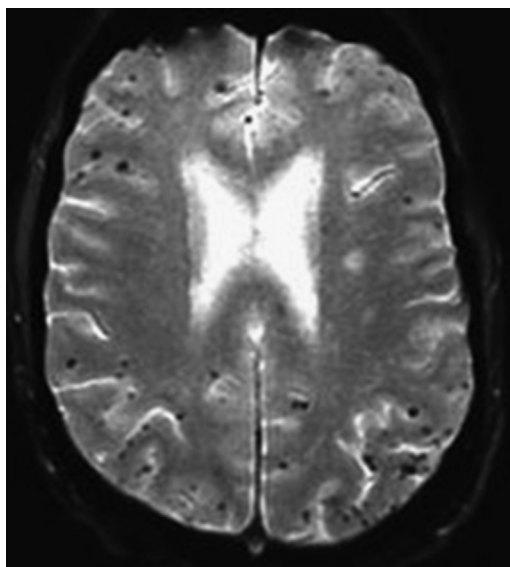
Magnetic resonance imaging of multiple cerebral microbleeds detected on spin echo gradient imaging. These microbleeds most likely represent amyloid angiopathy but may also be a marker for small vessel disease. (Data from Walker DA, Broderick DF, Kotsenas AL, et al. Routine use of gradient-echo MRI to screen for cerebral amyloid angiopathy in elderly patients. *Am J Roentgenol* 2004;182:1547–50.)
